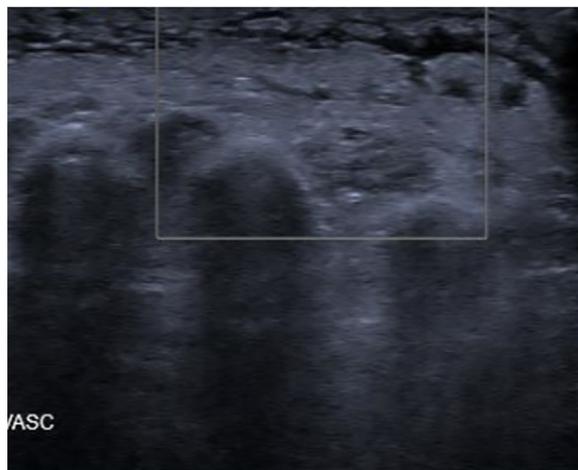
Ultrasound of left foot showing subcutaneous thickening with edema.
